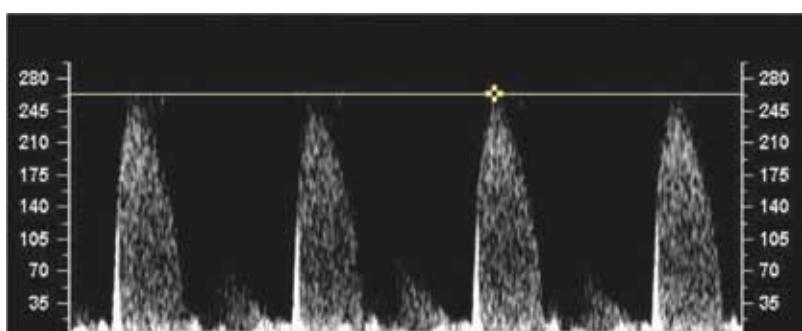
22 week of gestation Pulse Doppler. Flow into PA
